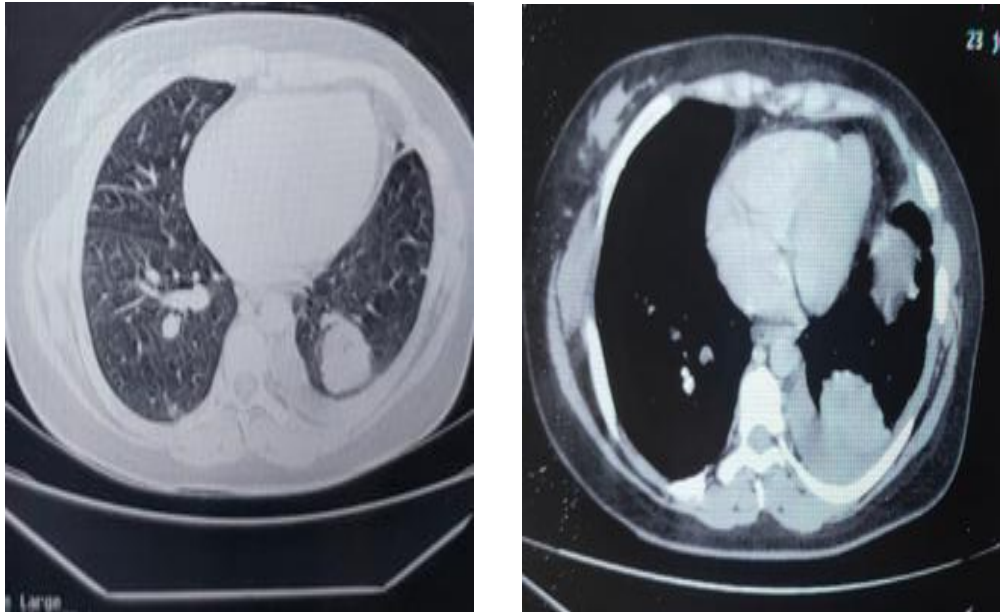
CT scan revealing a left basal consolidation with a Left pleural effusion
